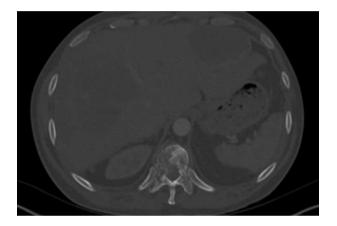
Destruction of the T10 vertebral body by Kaposi sarcoma and liver metastases on computed tomography (patient no. 4).
